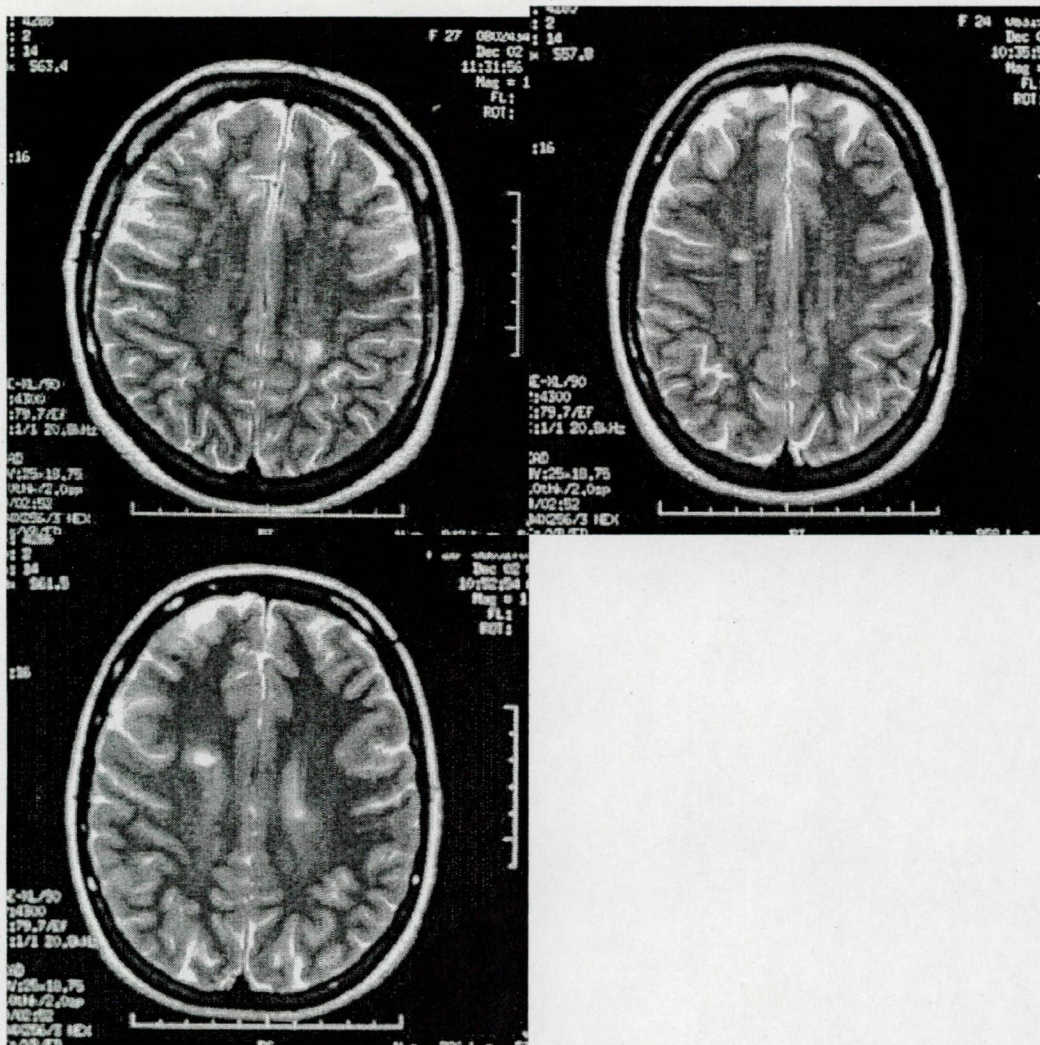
Magnetic resonance imaging of the brain – corresponding to demyelination (Patients I, II & III).
